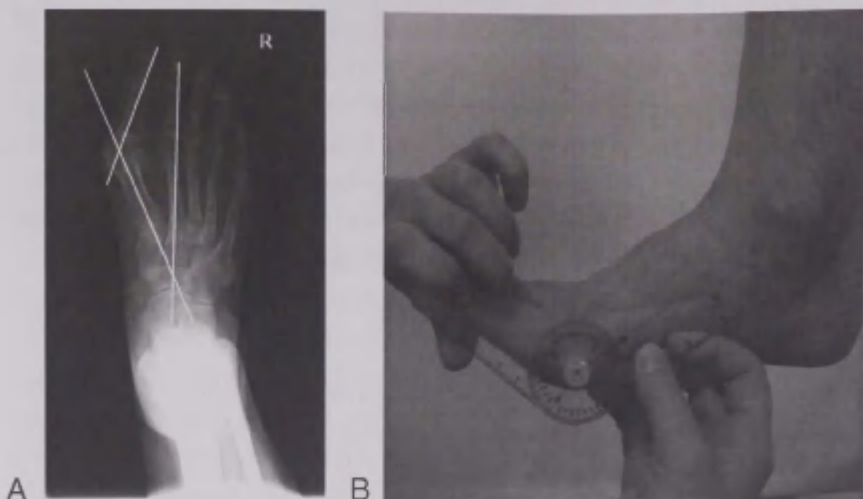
Measurement of first metatarsophalangeal joint angle and intermetatarsal angle in X-ray imaging of *Hallux Valgus* foot of right leg (A), and of passive range of motion of the first MTP joint flexion (B).
